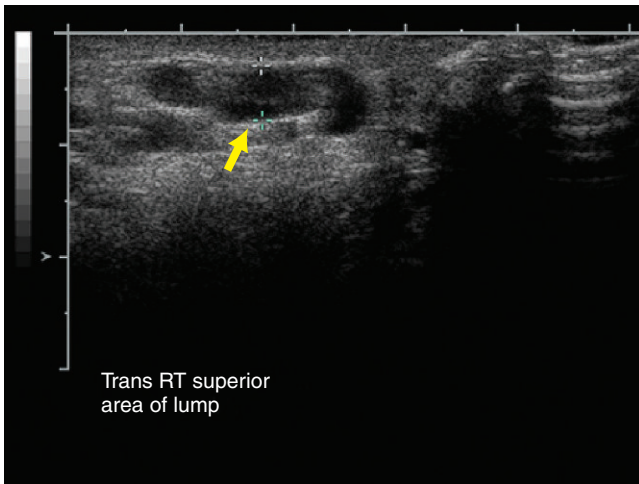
Transverse gray scale ultrasound through the right scrotal region shows a dilated 4.9-mm tubular structure just cephalad to the superior pole of the testis (arrow).
